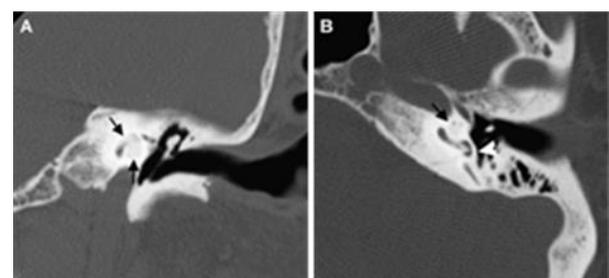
Labyrinthitis ossificans. (a) coronal slice and (b) axial cut CT scan of left temporal showing ossification of the middle groove and left apical cochlea of ossification labyrinthitis (black arrow), while the head of the white arrow indicates a normal cochlear promontorium
